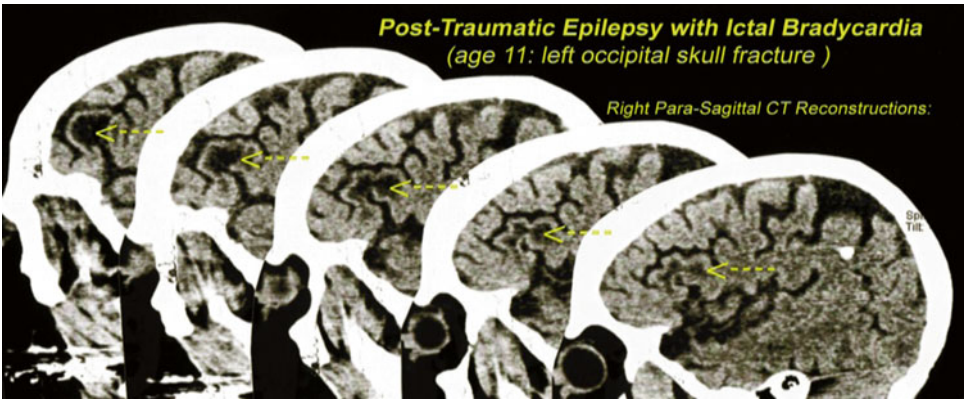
Post-traumatic epilepsy: CT findings
